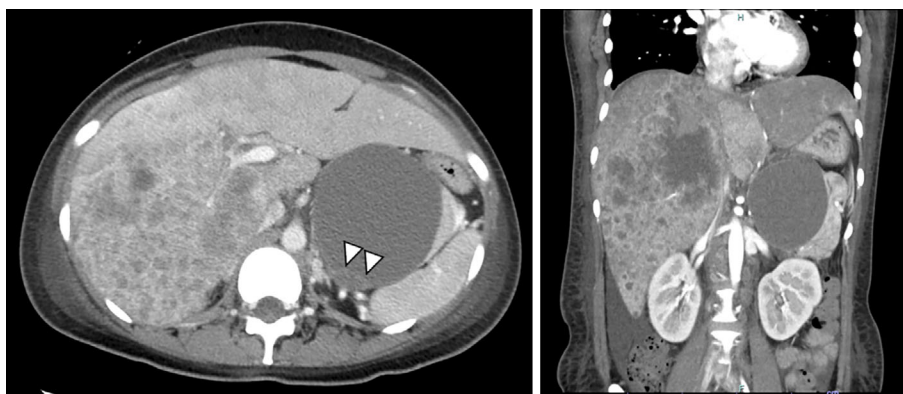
Abdominal computed tomography (A, B) showing a large mass with heterogeneous contrast enhancement occupying the right lobe of the liver and an 85-mm cyst with mural nodule (arrow heads, A) on the tail of the pancreas.
